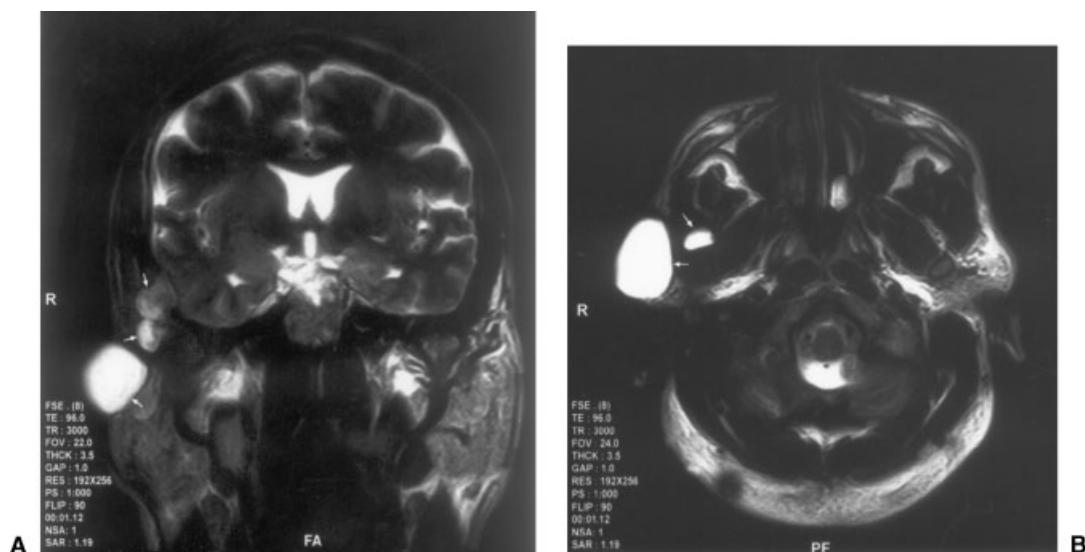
(A) Coronal and (B) axial magnetic resonance images show three separate masses enhanced by contrast material in the right superior parotid region and lateral skull base.
